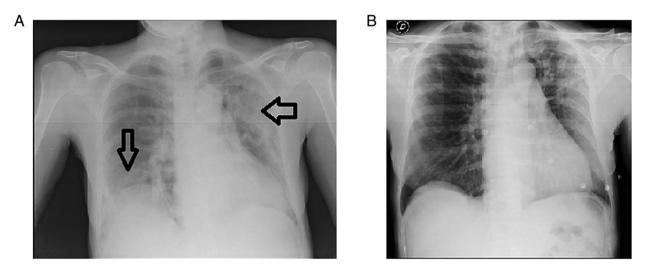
Chest X-ray results of the second patient in the present case series at (A) the time of admission and (B) upon improvement/discharge. Arrows indicate pathogenic lesions.
